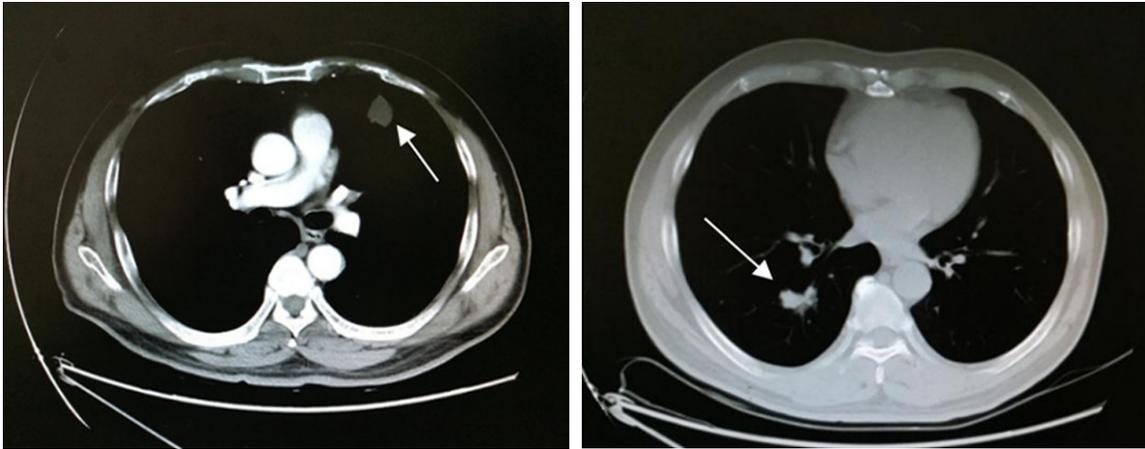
MRI image of the multiple lung metastasis of rectal adenocarcinoma.
